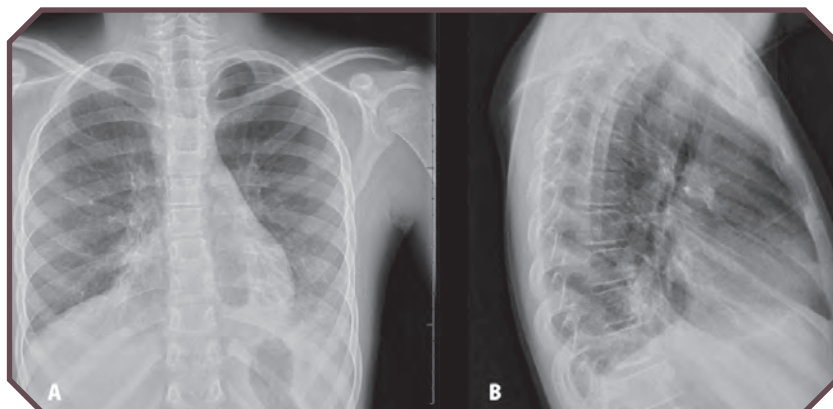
Bibasilar atelectasis in a 13-year-old boy with asthma. A chest radiograph with normal findings was obtained a few days earlier. A. Anteroposterior (frontal) and B. lateral views of the chest demonstrate tenting of the hemidiaphragms, secondary to volume loss.
